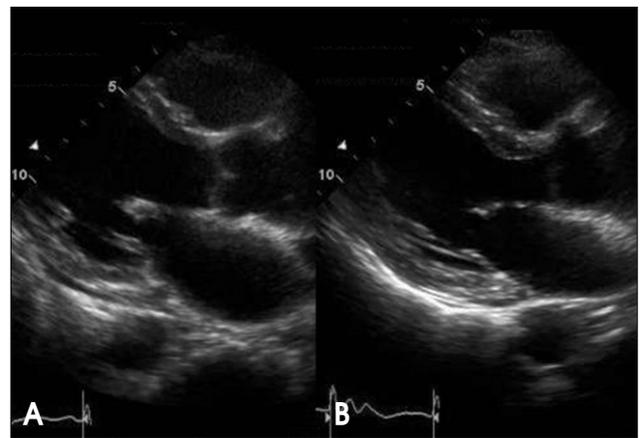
Parasternal long axis views on ER visit due to dyspnea (A) and 3 month later after discharge (B). Figures shows decreased left ventricular end diastolic dimension (6.2→5.5 cm) and decreased left atrial dimension (4.9→3.9 cm).
